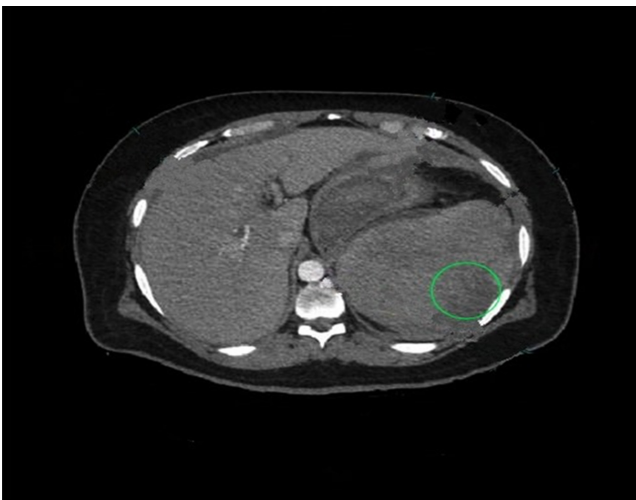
Follow-up computed tomographic scan of the abdomen representing regression of splenic hematoma represented by a green circle.
